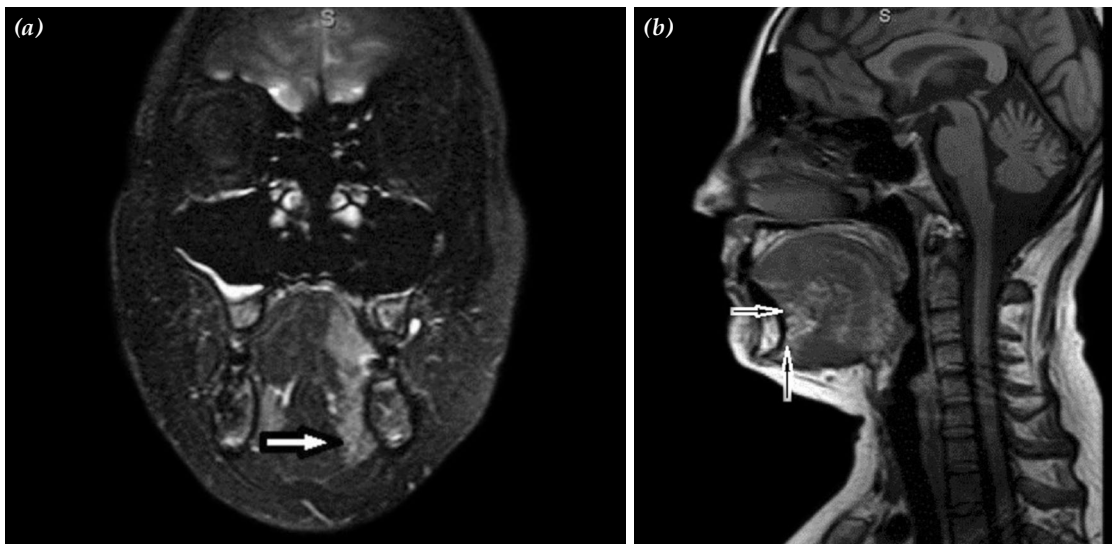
Magnetic resonance imaging of a patient with a 3.5x2 cm mass at the right side of the tongue staged as T₂ on clinical examination. (a) Coronal T₂ weighted magnetic resonance imaging revealed infiltration of genioglossus muscle (arrow) and the tumor was staged as cT₄. (b) Sagittal T₁ weighted magnetic resonance imaging also reveals the infiltration of genioglossus muscle (arrows).
